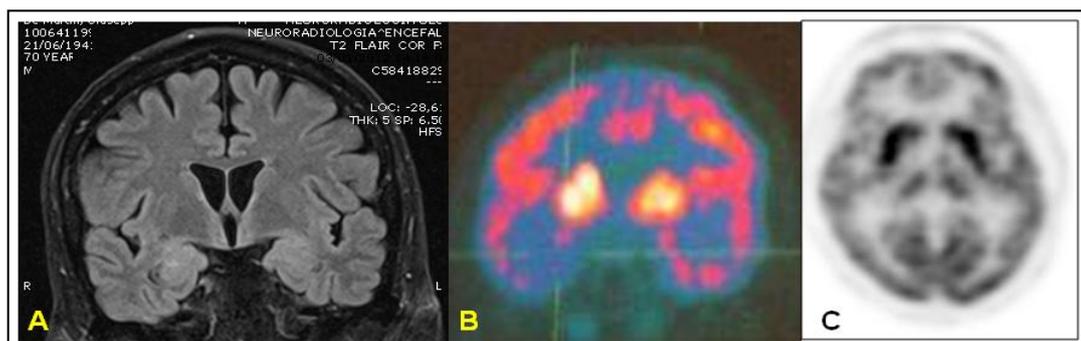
Patient 12's coronal brain MRI FLAIR images showing hippocampal swelling (A); Patient 2's 18-FDG brain PET scan showing increased bilateral striatal metabolism of radioligand 4 months after onset and during a phase of relative remission (B); Patient 3's 18F-FDG brain PET showing pathologically increased metabolism in basal ganglia (C).
